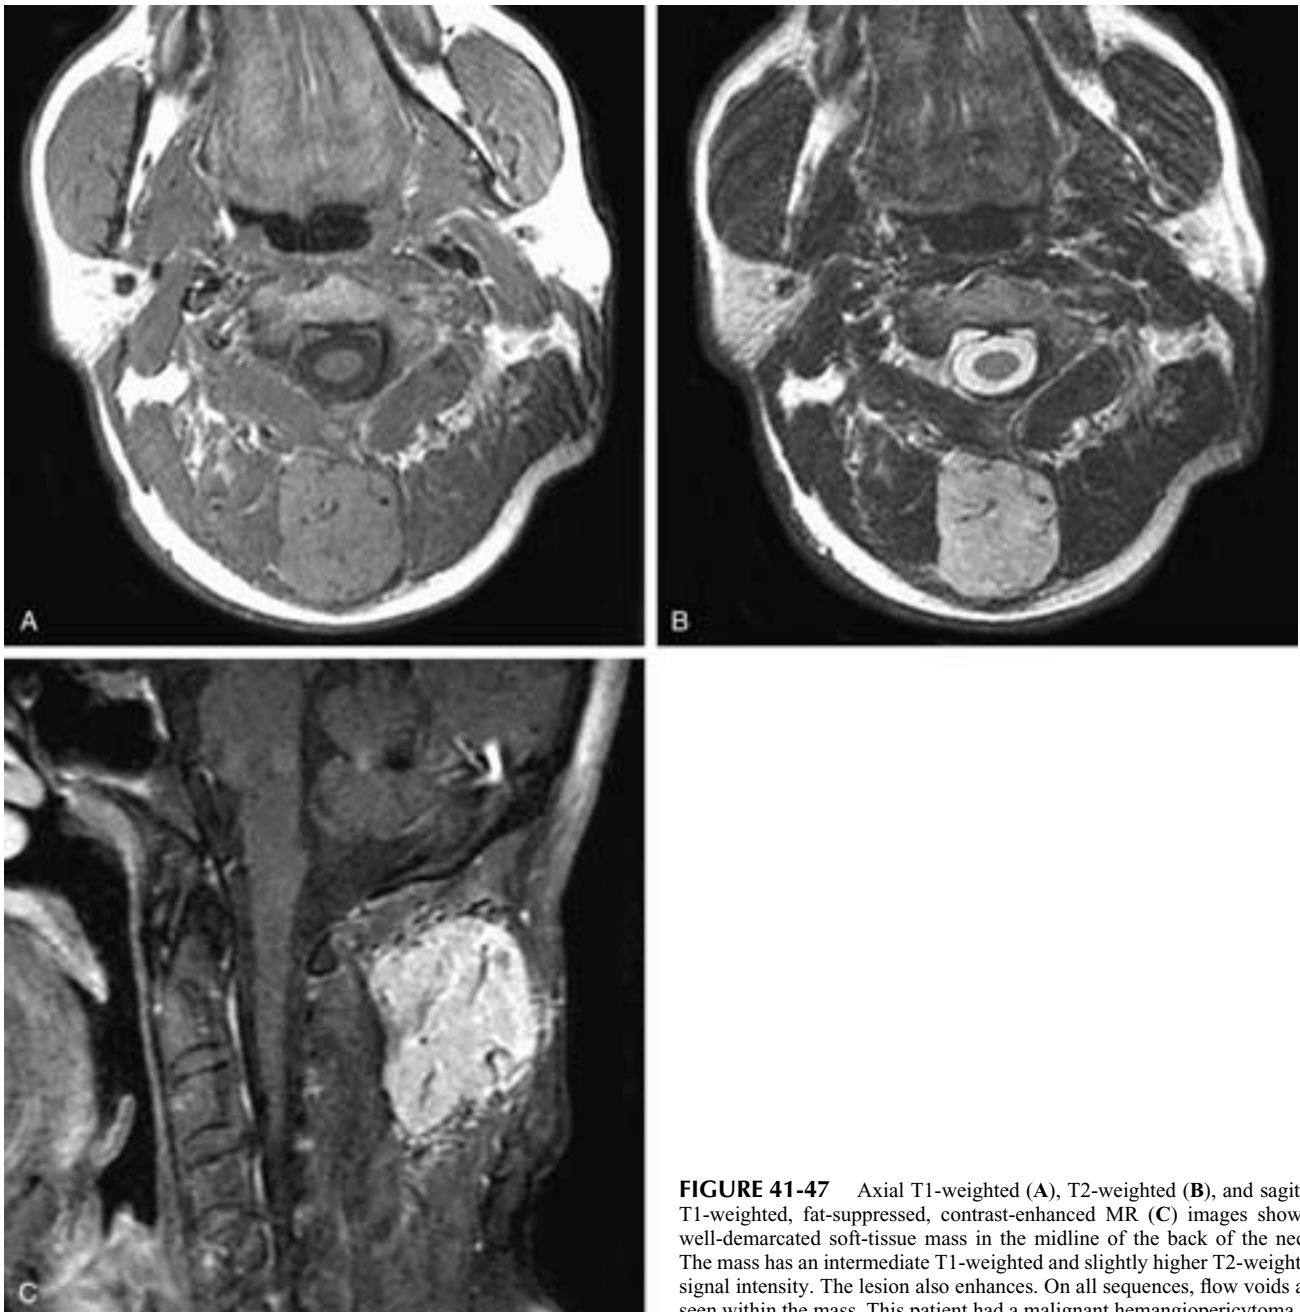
Axial T1-weighted (A), T2-weighted (B), and sagittal T1-weighted, fat-suppressed, contrast-enhanced MR (C) images show a well-demarcated soft-tissue mass in the midline of the back of the neck. The mass has an intermediate T1-weighted and slightly higher T2-weighted signal intensity. The lesion also enhances. On all sequences, flow voids are seen within the mass. This patient had a malignant hemangiopericytoma.
